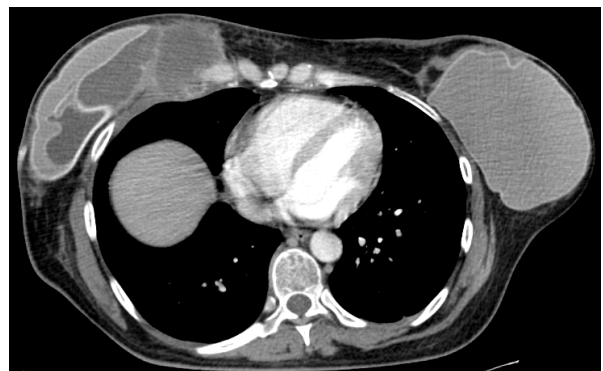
Axial section of contrast chest CT. An infiltrating hypodense solid mass with peripheral enhancement located in the costosternal junction can be seen on the right thoracic wall
